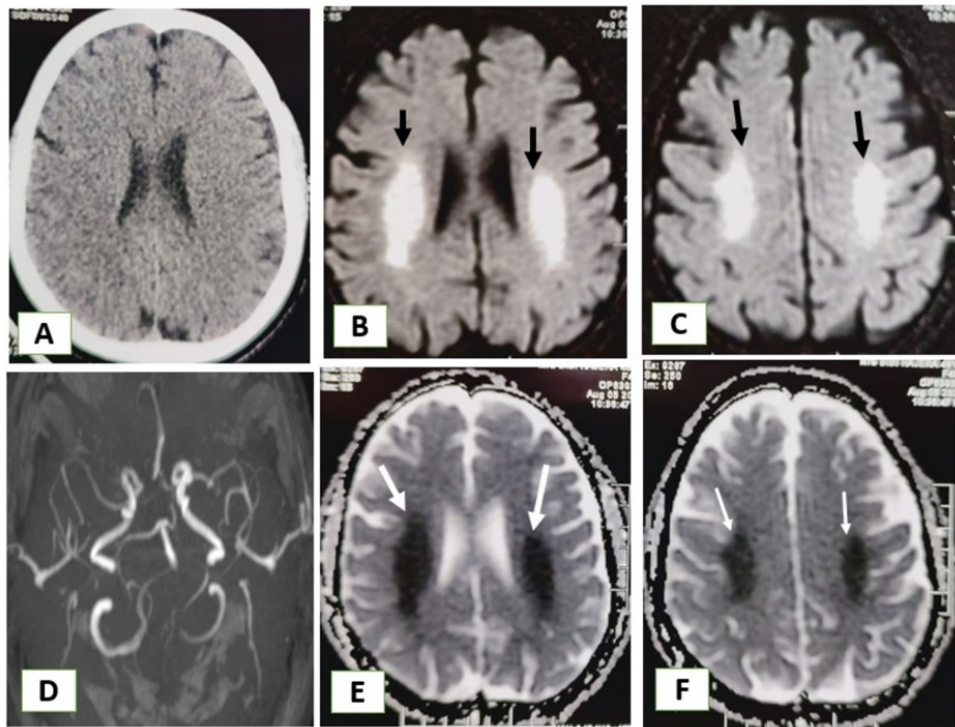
Computed tomography brain (A) showing normal brain parenchyma at the level of body of lateral ventricle, there are hyperintensity involving bilateral semicentrum ovale in diffusion weighted images (B, C), with corresponding hypointensities on ADC (adsorption diffusion coefficient) images (E, F) consistent with symmetrical cytotoxic edema in semicentrum ovale. MRA (Magnetic resonance angiography) showed normal angiography (D) except attenuated left vertebral artery.
